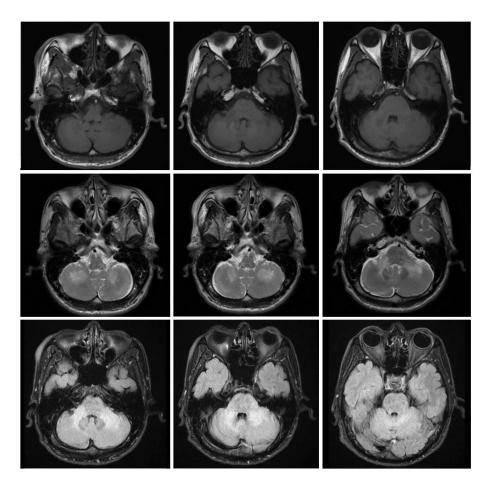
MRI brain (Front cover)
